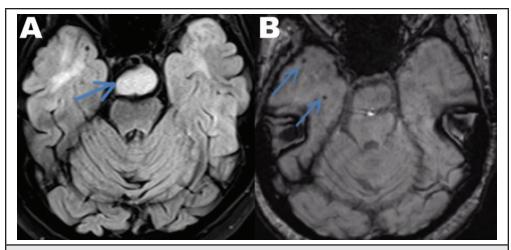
(A) Axial T2 FLAIR demonstrates abnormal T2 hyperintensity within the anterior temporal lobes. The hypothalamic hamartoma is visible within the preportine cistern (arrow). (B) Axial susceptibility weighted imaging demonstrates foci of susceptibility consistent with hemosiderin (arrows).
